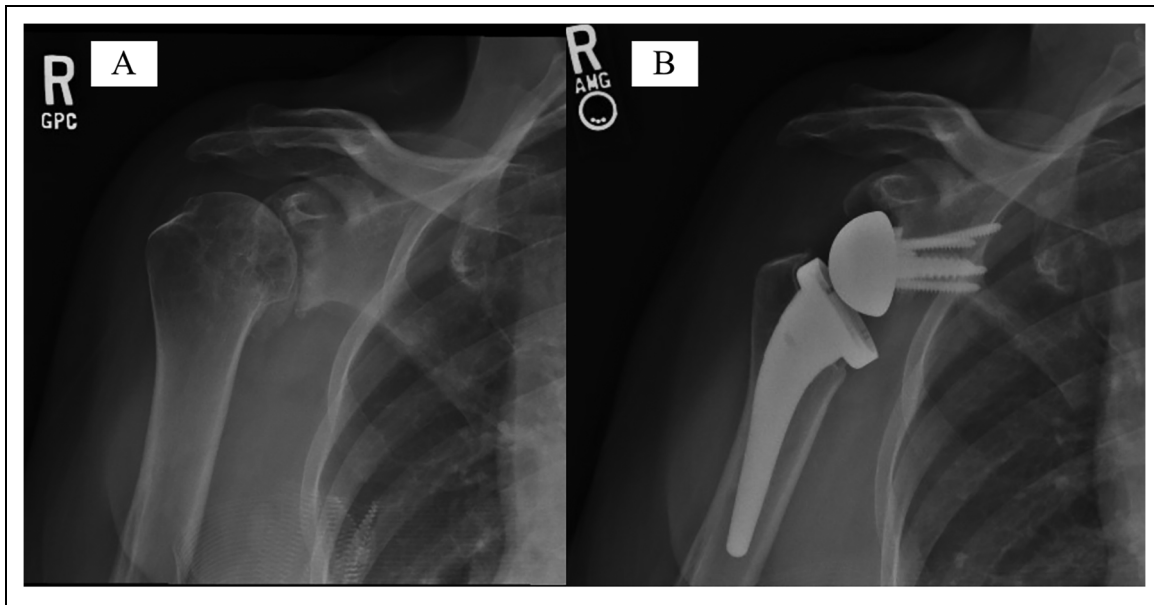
(A) Preoperative and (B) postoperative radiographs of a 67-year-old woman treated with RTSA using a metallic augment baseplate.
